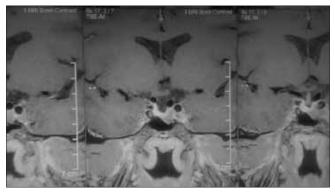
T1-weighted magnetic resonance imaging brain, coronal section showing sellar mass causing deviation of pituitary stalk
